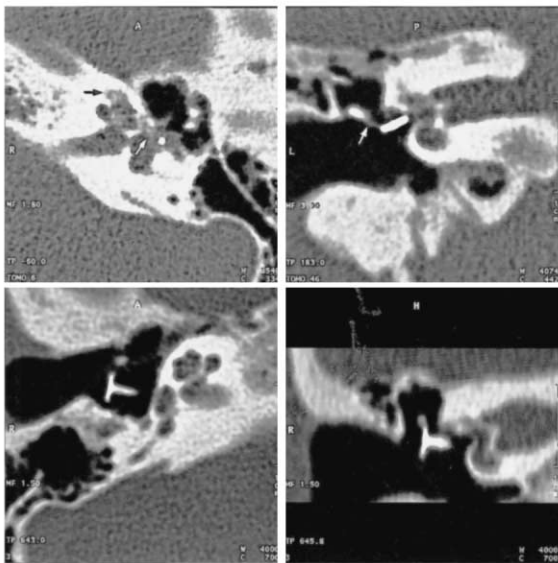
Three patients with hearing loss after stapes surgery. Upper line left: a patient after stapedotomy because of otosclerosis and progressive combined hearing loss. Axial CT shows cochlear (black arrow) and fenestral (white arrow) otospongiotic foci. The position of the prosthesis is correct. Upper line right: a patient after stapedotomy because of otosclerosis and conductive hearing loss. Coronal CT shows a thinning of long process of incus (arrow). An incus necrosis was suggested. CT finding was confirmed by retympanotomy. Lower lines: a patient after insertion of TORP because of stapes aplasia. Axial CT and coronal MPR show TORP without contact to the oval window.
